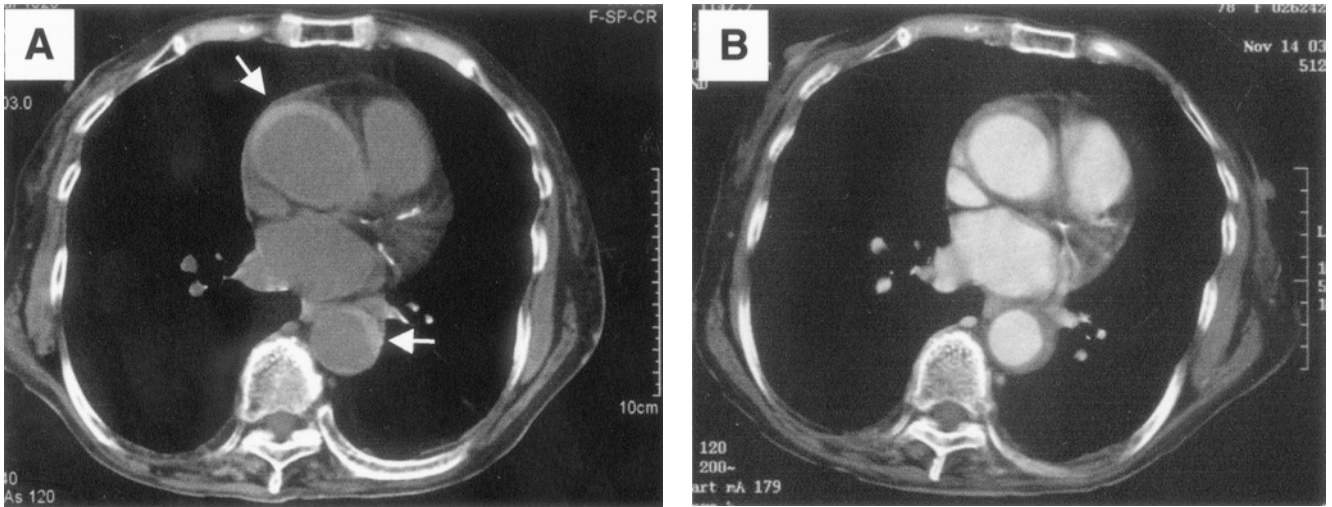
Computed tomography (CT) on November 14, 2003. A. A plain CT: Ascending aorta showed mild dilation (about 4.5 cm in diameter) and a crescent-shaped high density lesion was seen in the region of the ascending to descending aorta (arrows). B. A contrast-enhanced CT showed absence of opacification of the high-density region observed on the plain CT. It indicates a thrombosed-type aortic dissection.
